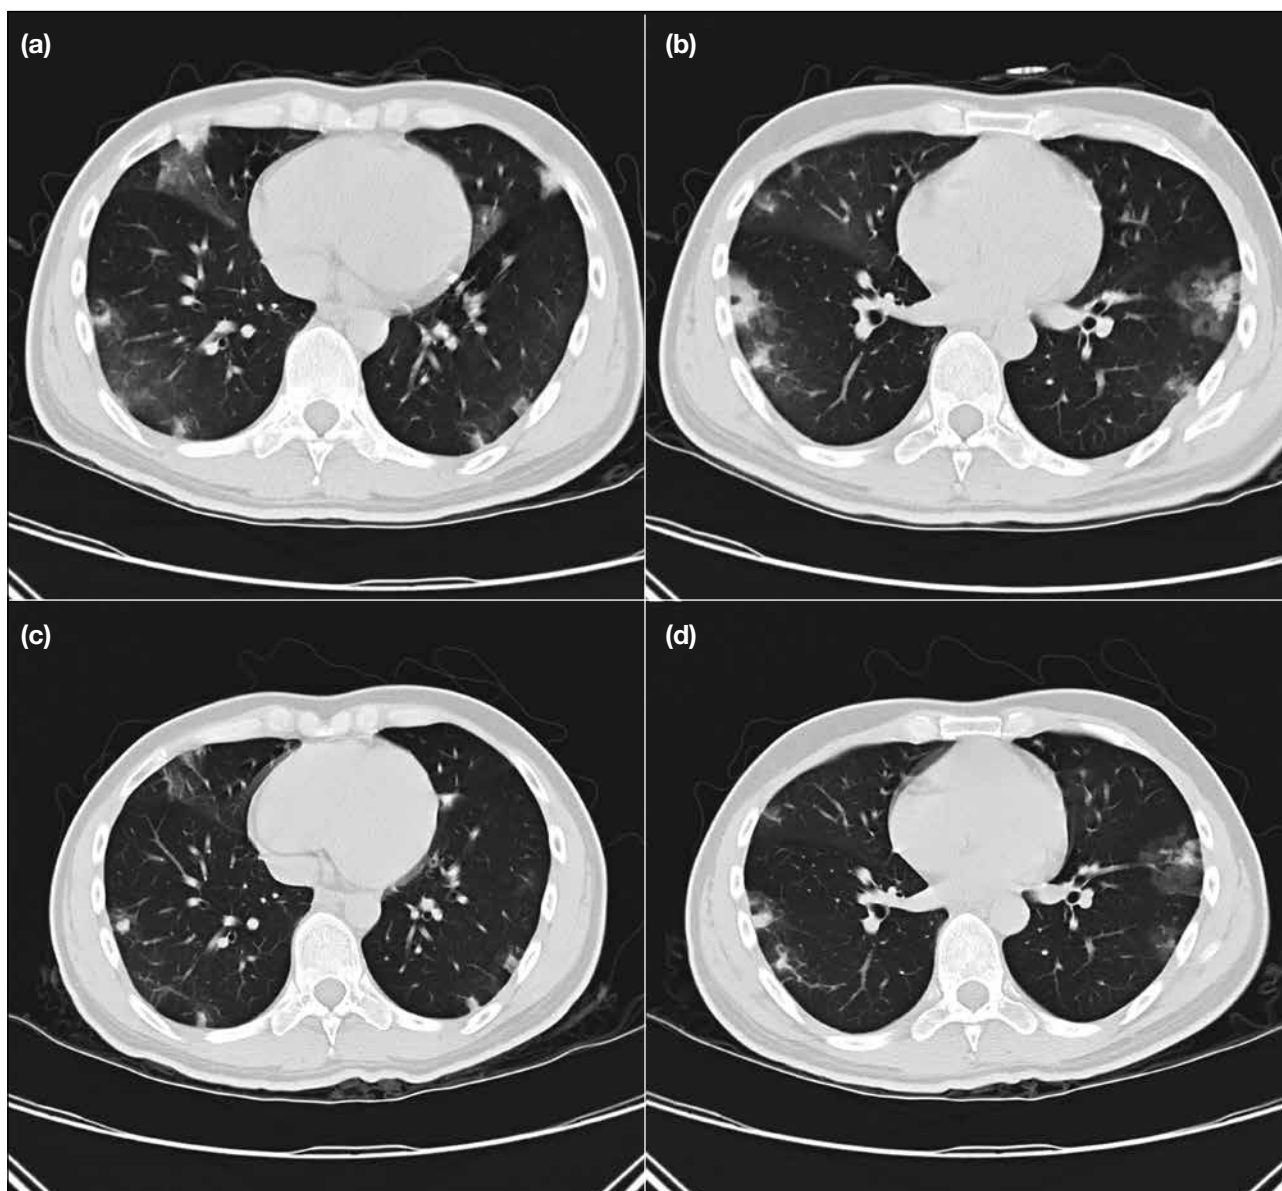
(a) & (b) Initial computed tomography scans of the thorax showed bilateral subpleural consolidation and ground-glass opacities. (c) & (d) New computed tomography scans of the thorax taken 4 days later showed a mild decrease in size of bilateral lung consolidative subpleural lesions.
